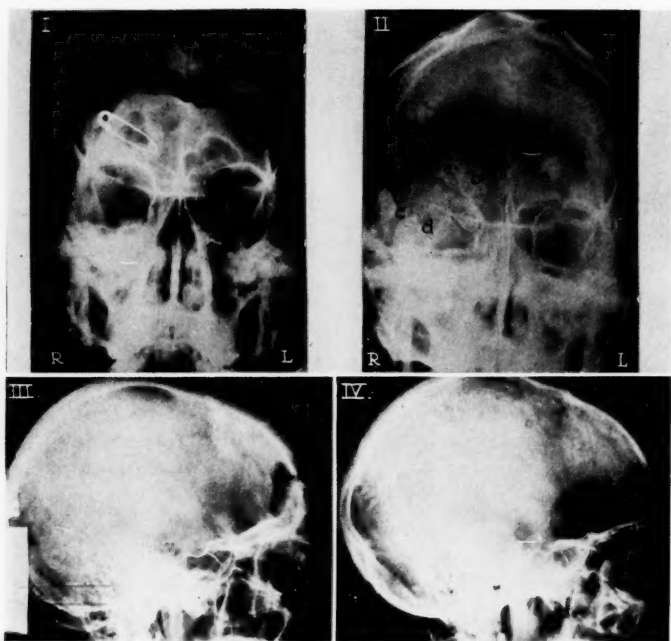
X-ray films of the skull in Case 5. Film I was taken on October 22, 1941. The osteomyelitic area is separated from the frontal squama.
